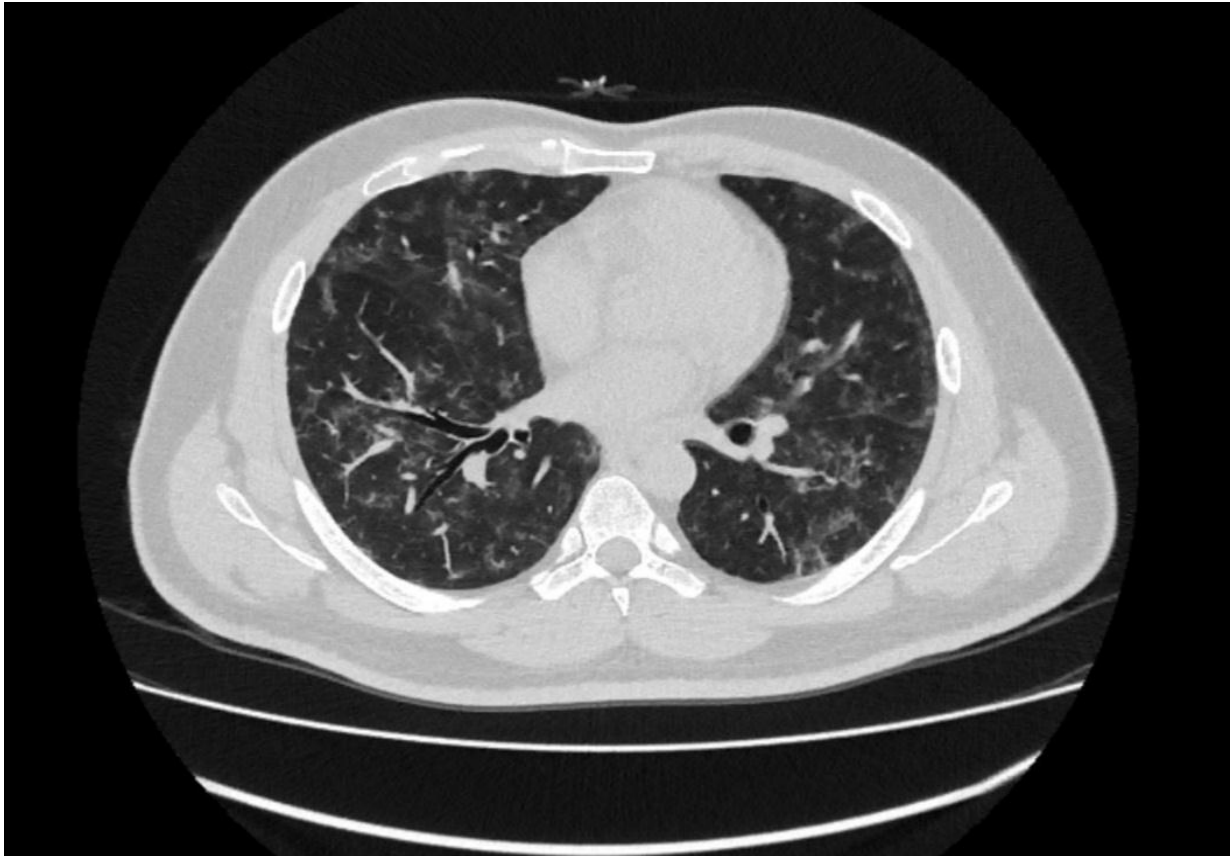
CT Chest revealing bilateral patchy infiltrates.
